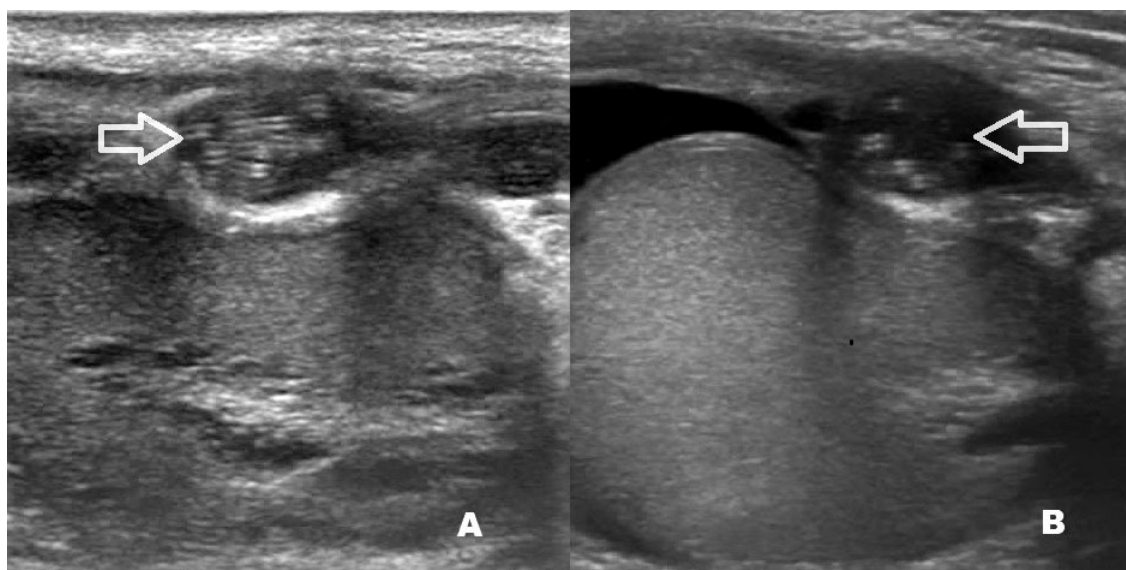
During USG examination with a 12 MHz linear ultrasound probe in the area of the epididymis, a coiled worm (A, B) is observed, marked with an arrow
